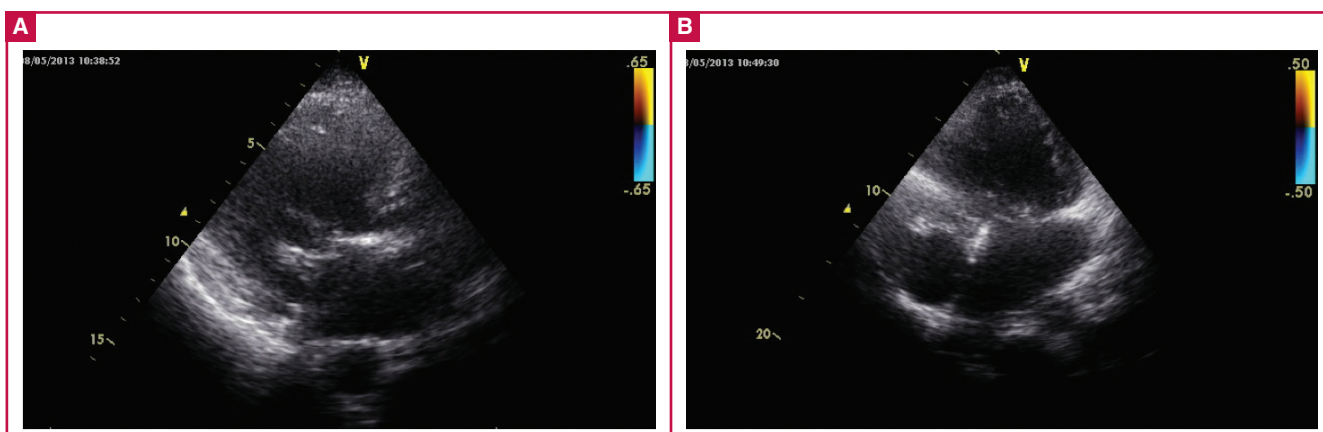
Transthoracic echocardiographic images in the parasternal long-axis and apical four-chamber views.
